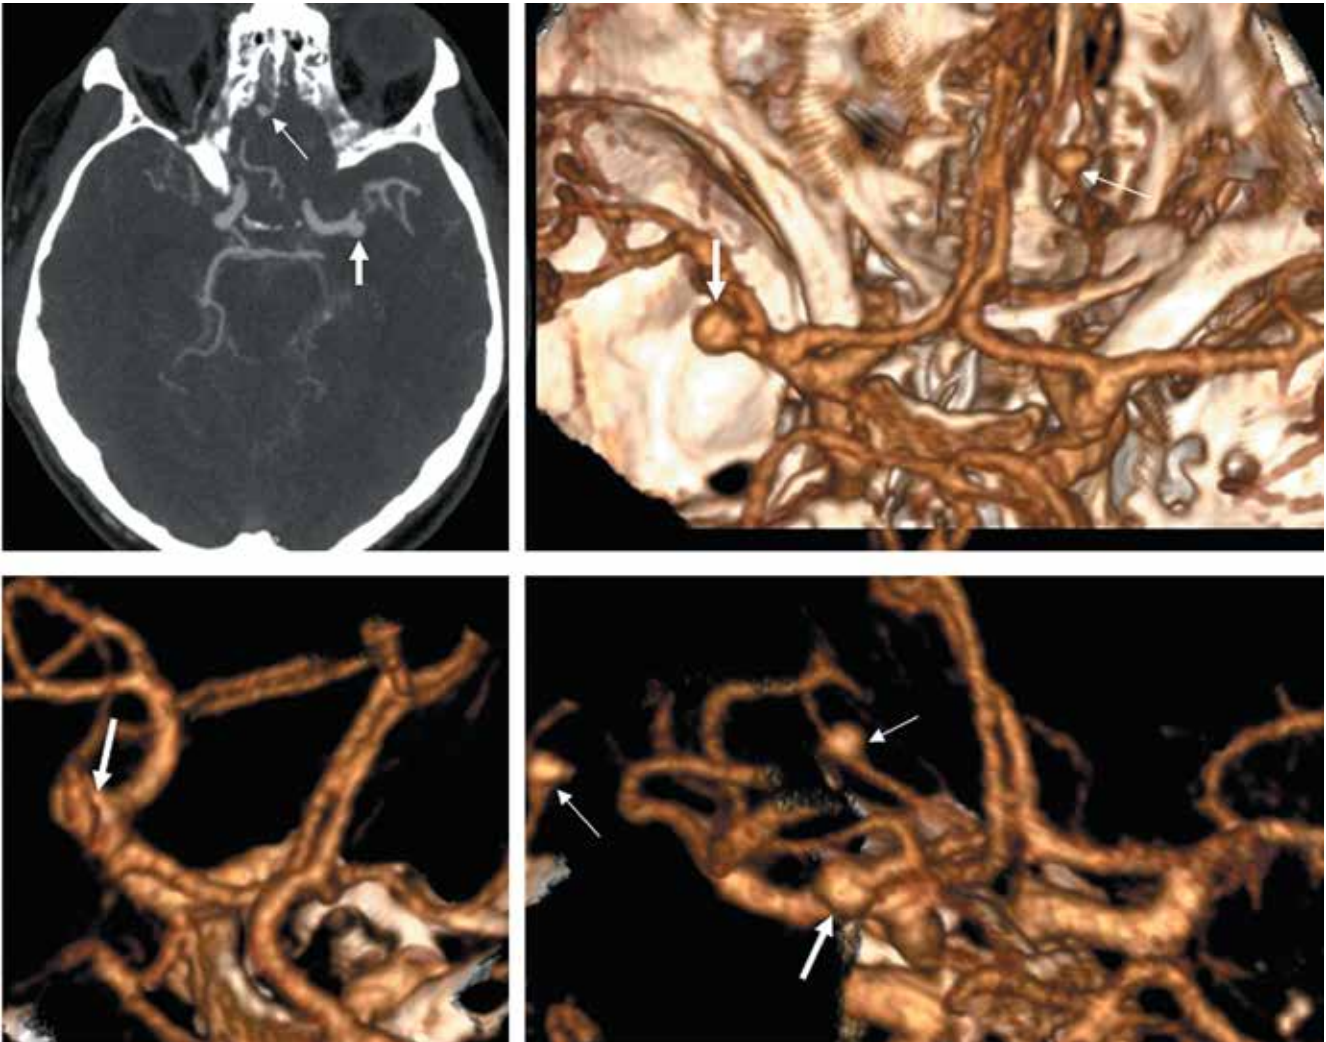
Multislice computed tomography angiography of patient T. A thick white arrow indicates an aneurysm of the M1-segment of the left middle cerebral artery. A thin white arrow indicates an aneurysm of the distal sections of the hypertrophied medial frontobasal artery
